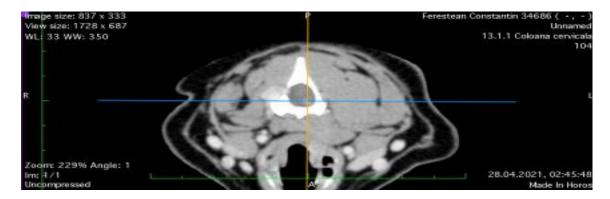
Axial CT image invasive mass-like lesion leaving the medullary canal to the right side through the supravertebral foramen on the C1-C2 segment.
